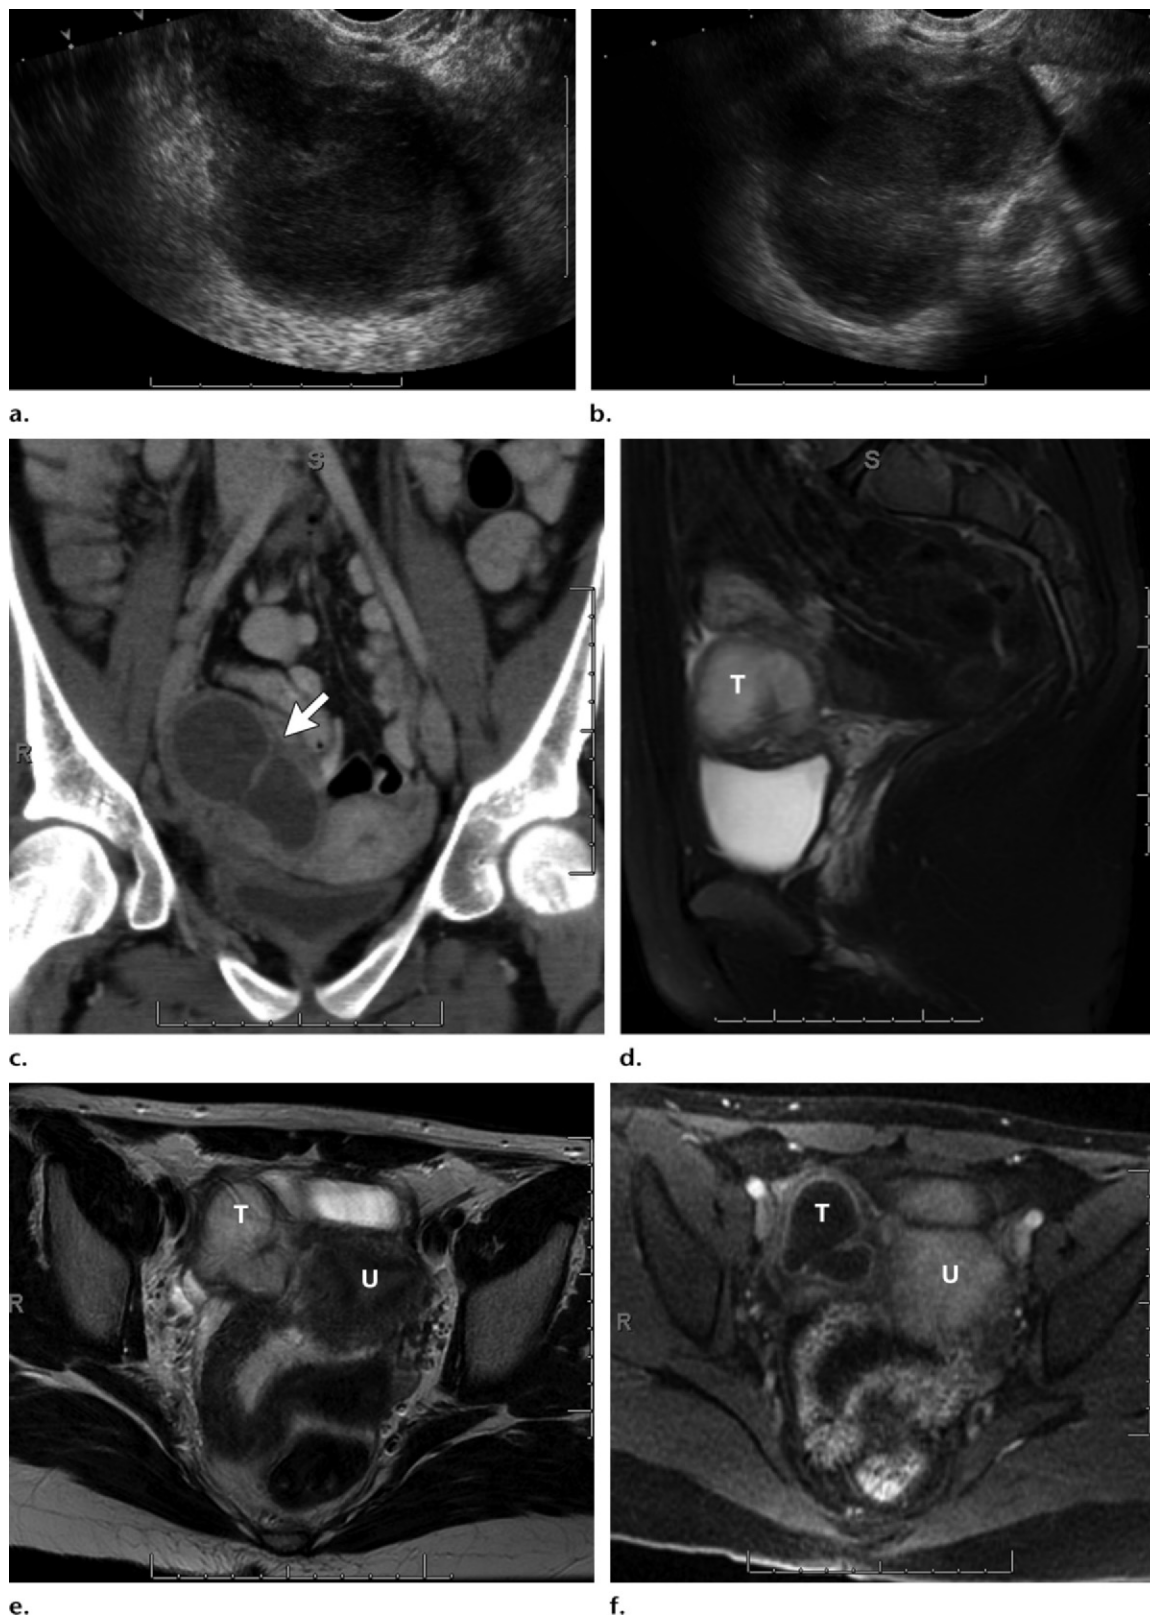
Tubo-ovarian abscess in a 37-year-old woman. (a, b) Sagittal (a) and coronal (b) endovaginal pelvic US images show a dilated, thick-walled, tubular structure that contains internal echoes in the right adnexa. (c) Coronal CT image obtained later the same day shows the dilated, thick-walled, tubular right adnexal structure with an incomplete septum (arrow) just lateral to the uterus. (d–f) Sagittal (d) and axial (e) T2-weighted and axial contrast-enhanced fat-suppressed T1-weighted GRE (f) images show the dilated, thick-walled, tubular right adnexal cystic structure (*T*) adjacent to the uterus (*U* in e and f) with rim enhancement after contrast material administration, findings consistent with a tubo-ovarian abscess.
